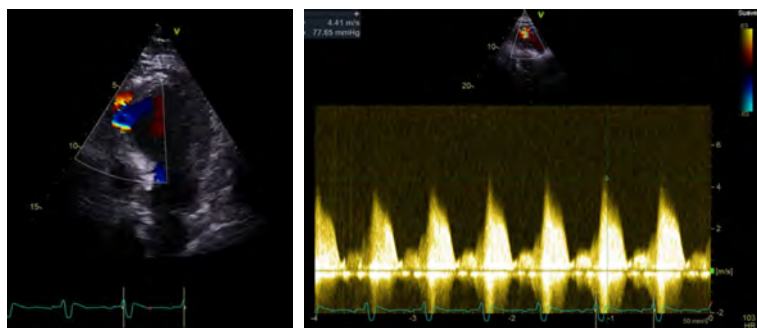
Echocardiogram shows a defect of the interventricular septum at the apical level with a speed of 4.4 m/s and a maximum gradient of 77.6 mmHg.
